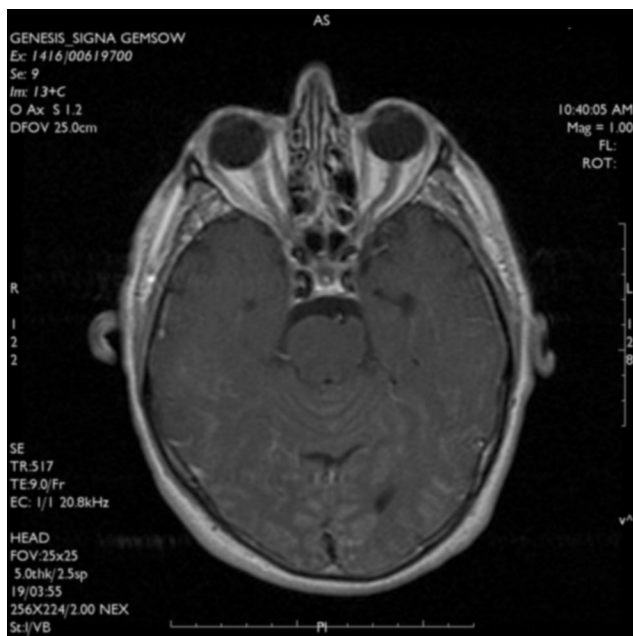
Day 1, T1-weighted contrast enhanced magnetic resonance image at 2 h after cervical transforaminal injection demonstrating intense parenchymal uptake in bilateral occipital and temporal lobes compatible with acute disruption of the blood-brain barrier.
